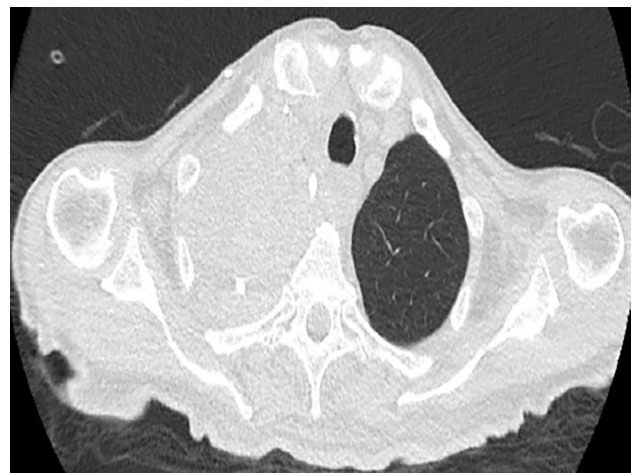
Computed tomography angiography demonstrating right hemothorax and contrast accumulation in the right pleural cavity.
